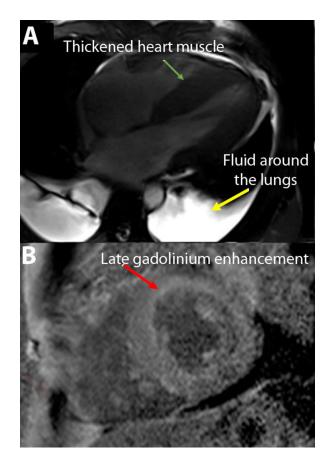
MRI of the heart in cardiac amyloidosis. Panel A shows increased wall thickness of the left ventricle (green arrow) and fluid around the lungs (yellow arrow). Panel B shows diffuse late gadolinium enhancement (gray color, red arrow) of the entire left ventricle (normal appearance on these images should be black). These features are commonly seen in cardiac amyloidosis.
